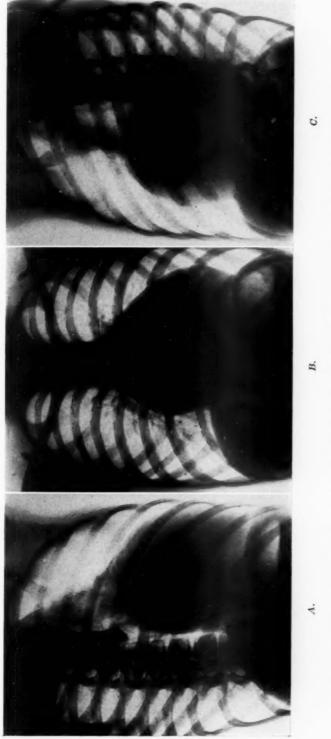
Roentgenograms of Case 1. A, Right anterior oblique position; B, Anteroposterior view; C, Left anterior oblique position.
